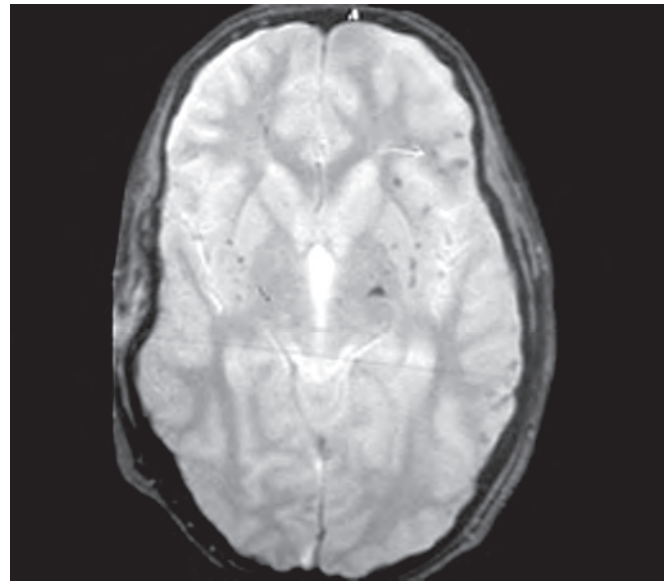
Gradient-echo axial MRI demonstrating numerous small foci of diminished signal consistent with the paramagnetic effect of the haemoglobin content of many acute haemorrhages
